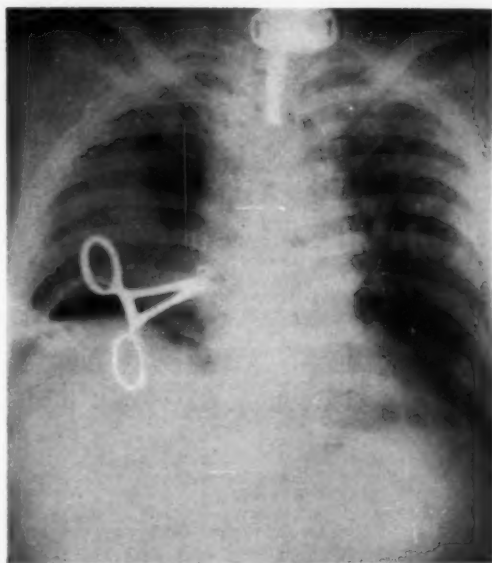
(case 2). Roentgenographic appearance prior to admission to the clinic, showing tracheotomy tube in place and towel clip for traction on right anterior thoracic wall. Mediastinal and subcutaneous emphysema was present.
